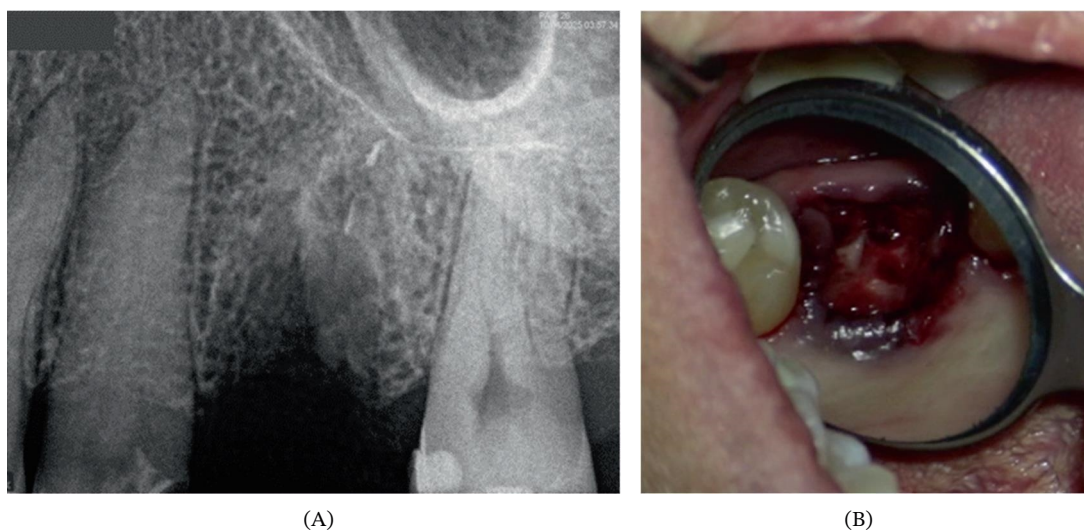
Periapical radiograph (A) and photograph (B) demonstrating extraction of Ttooth #14 due to extensive carious involvement and the presence of a separated endodontic instrument within the canal system. Notably, no radiographic evidence of root fracture is observed in the adjacent maxillary second molar (tTooth #15).
